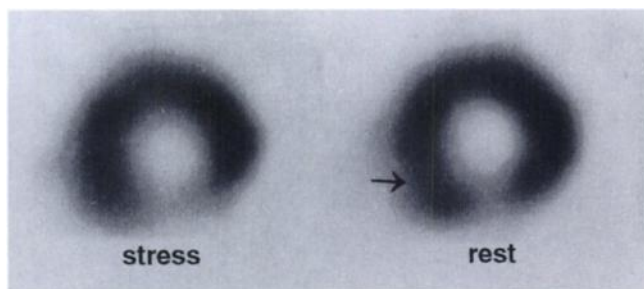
Stress-redistribution ^{99m}Tc -MIBI myocardial SPECT (short-axis) performed 6 mo prior to Figure 1 images show relatively decreased uptake in the inferior septal wall (arrow) during redistribution and normal uptake during stress (reverse redistribution), fixed inferior hypoperfusion and presence of transient LV dilatation.
